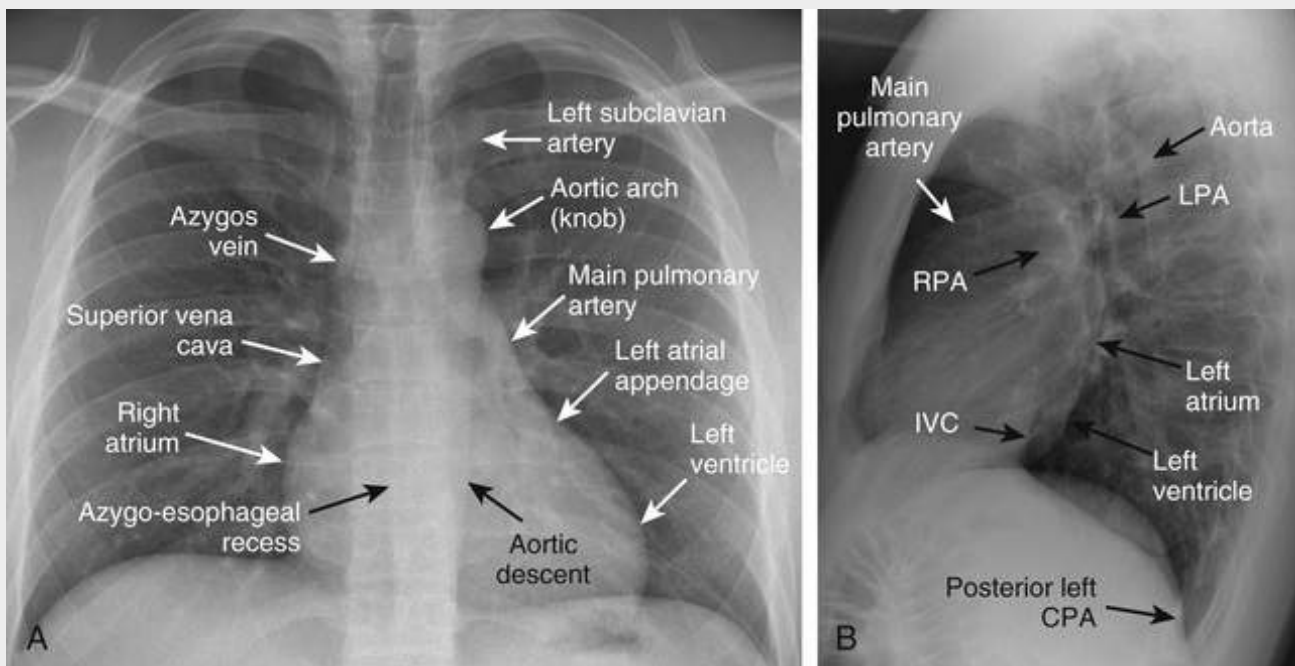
Normal standard two-view chest radiograph. PA (A) and lateral (B) views of the chest depict various normal cardiovascular structures. CPA, Costophrenic angle; IVC, inferior vena cava; LPA, left pulmonary artery; RPA, right pulmonary artery.
